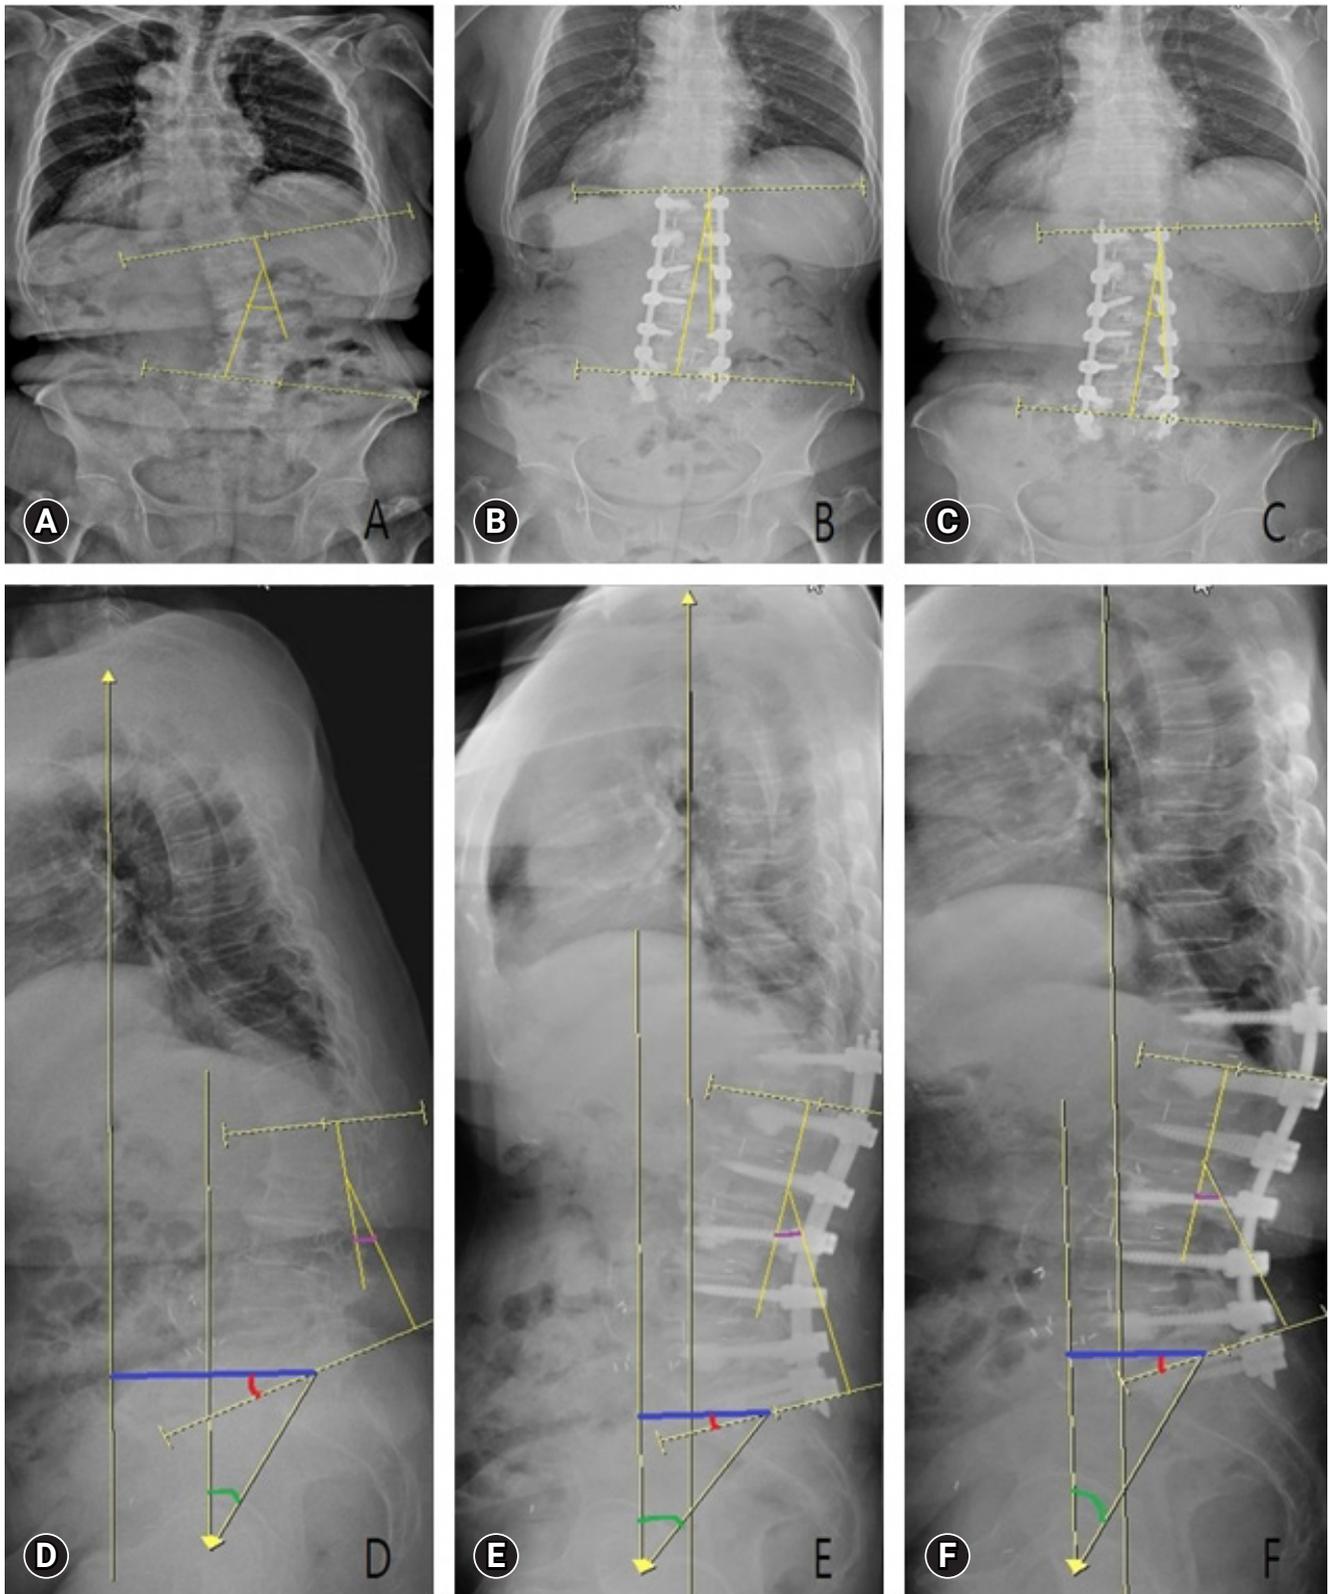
Female, 77-year-old, T=-2.1 SD, the patient underwent PPF with bone cement augmentation. (A) The preoperative A-P view X-ray image measured Cobb's angle; (B) Postoperative A-P view X-ray image measured Cobb's angle; (C) Last follow-up A-P view X-ray image measured Cobb's angle (yellow angle); (D) The preoperative lateral view X-ray image measured SVA (blue line), PT (green angle), SS (red angle), and LL (purple angle); (E) Postoperative lateral view X-ray image measured SVA, PT, SS, and LL; (F) Last follow-up lateral view X-ray image measured SVA, PT, SS, and LL.
